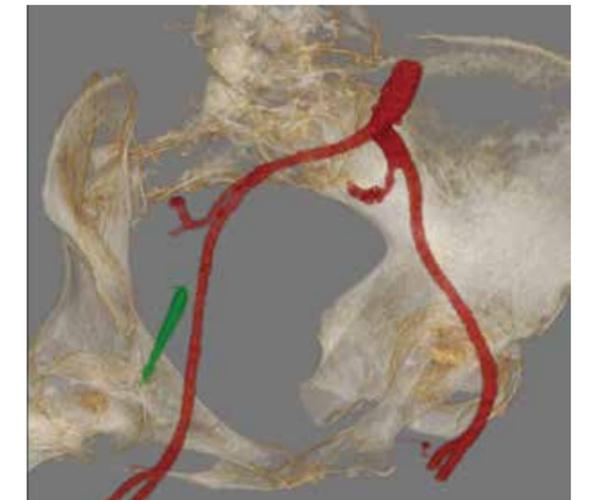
Image on left shows the biopsy needle insertion. Image on right is the CT with IV contrast injection to check the needle pathway
